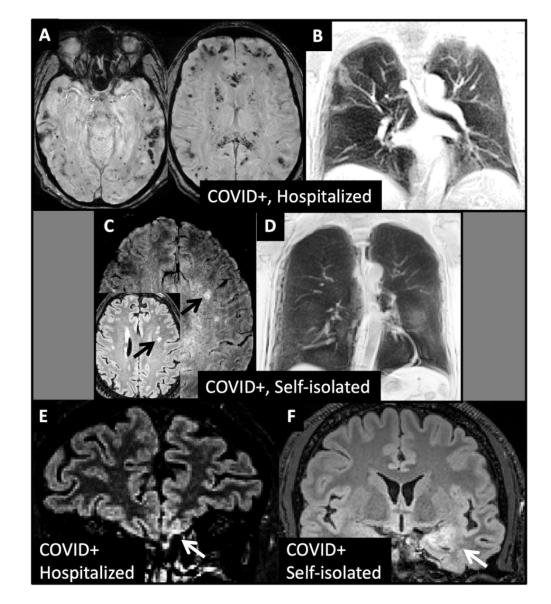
Brain and lung images from a selection of study participants. Top: a COVID+ male in his 50's who spent >12 days on a ventilator before recovering showed (A) numerous moderate sized lesions on SWI and (B) substantial abnormal signal intensities on lung imaging. This individual had severely impaired olfaction and moderate behavioural impairment (NIH toolbox 17th percentile on working memory, and complete inability to discriminate previously seen items from similar lures). He has been referred to a neurology clinic for follow-up. Middle: a COVID+ male in their 50's who self-isolated and showed micro-lesions in (C) SWI and T2 FLAIR imaging (inset), with (D) corresponding lung image with diffuse changes. Olfaction and sensory/behavioural tests were within age norms but self-report indicated difficulty in performing activities of daily living involving memory. Bottom: a COVID+ female in their 50's with moderately impaired olfaction and (E) elevated T2-FLAIR signal near the olfactory bulb and orbitofrontal cortex; and a COVID+ male in their 30's with an encephalitis-like lesion in the temporal lobe as observed (F) on T2-FLAIR imaging.
